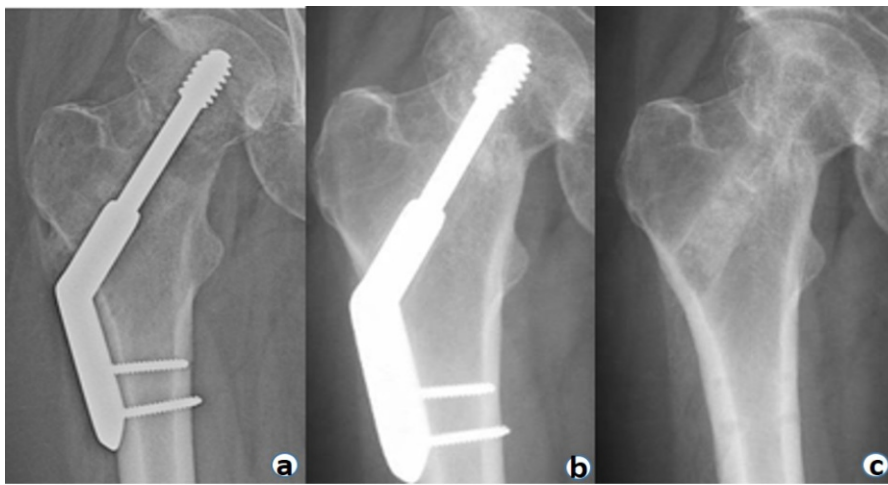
Post-operative X-rays (a), Bone union at 6 months (b), and hardware removal at 2-year post-operative (c) in the 32-year-old patient. (a) Immediate post-operative, (b) 6-month post-operative, (c) at 2-year post-operative
